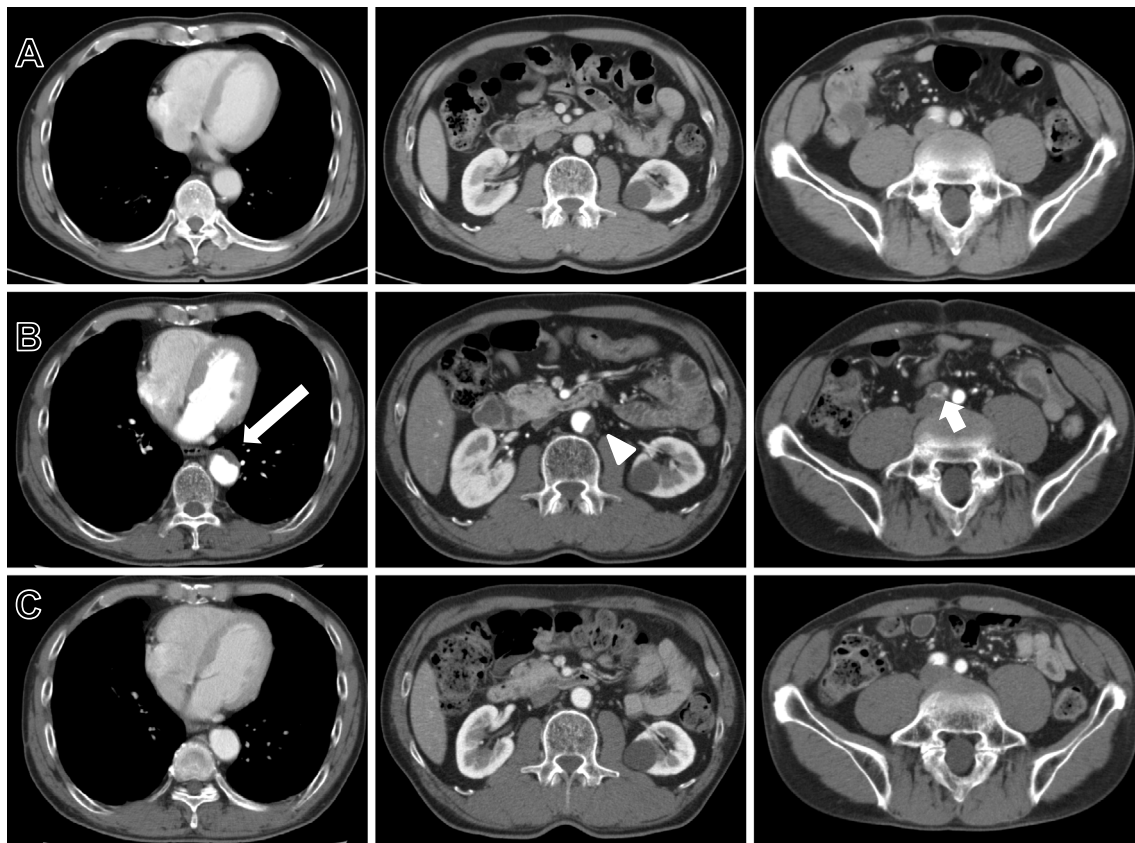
Contrast-enhanced computed tomography scans. (A) At the diagnosis: there was no thrombus. (B) At the onset of thromboembolic events (TEEs): a low-density intraluminal lesion (thrombus) was detected at the level of the descending aorta (long arrow), abdominal aorta (short arrow), and common iliac artery (arrowhead). (C) After the onset of TEEs (day 115): the thrombus was no longer present.
